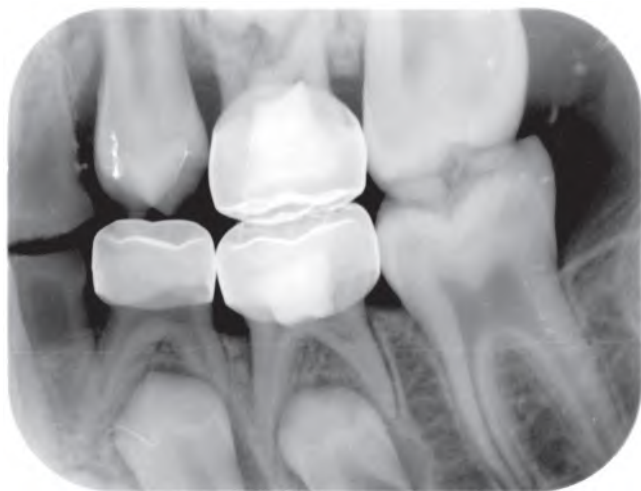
Bite-wing radiograph taken several months after pulpotomies were performed in the primary maxillary and mandibular left second molars. Note the obliteration of the root canals in both molars, and internal resorption, partially calcified, at the distal root of the mandibular second molar.
